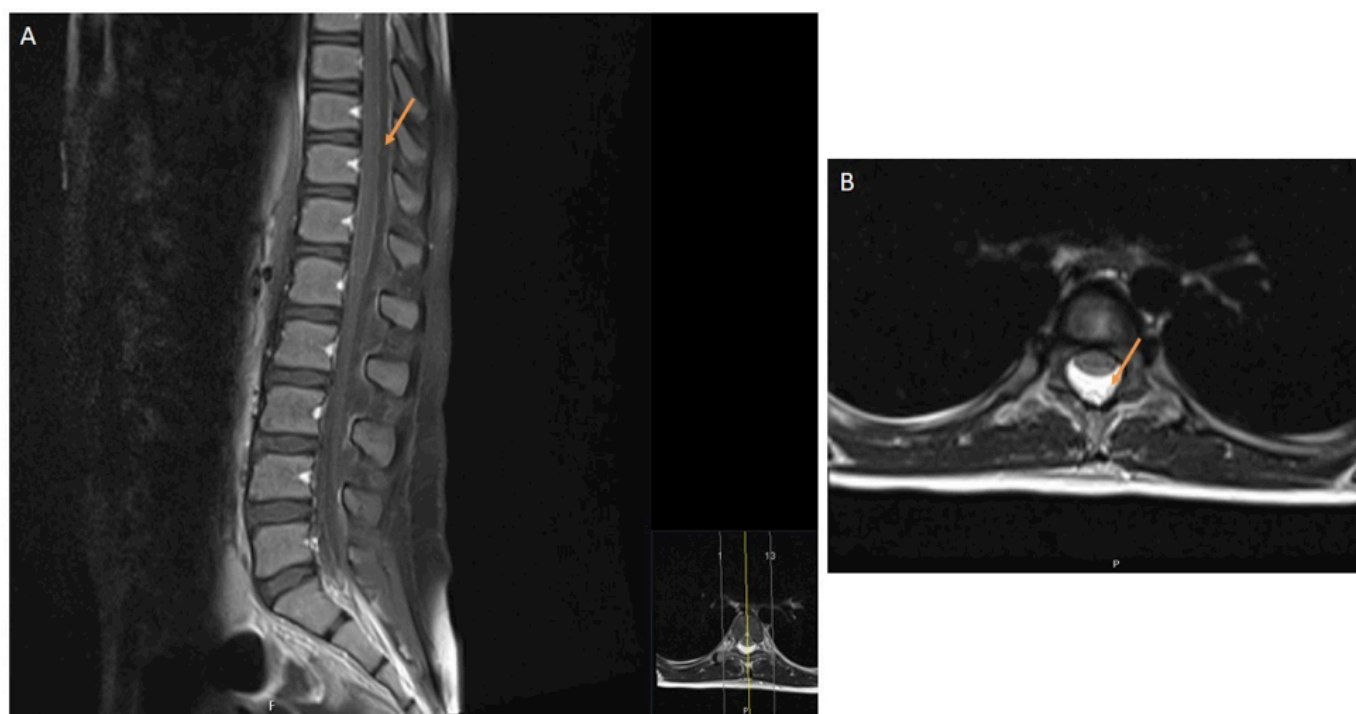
Spinal MRI. (A) Sagittal view and (B) axial view showing an extensive dorsal and lumbar spinal epidural fluid collection and an anterior displacement of the thecal sac with reduction of the subarachnoid space.
